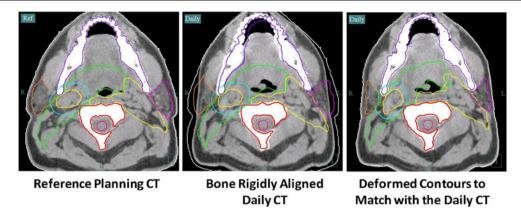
The ART process starts with rigid alignment between the reference planning CT and the daily in-room CT (*left* and *middle*). The planning contours are overlaid to the daily CT to verify setup accuracy and to evaluate changes in anatomy relative to baseline. If
